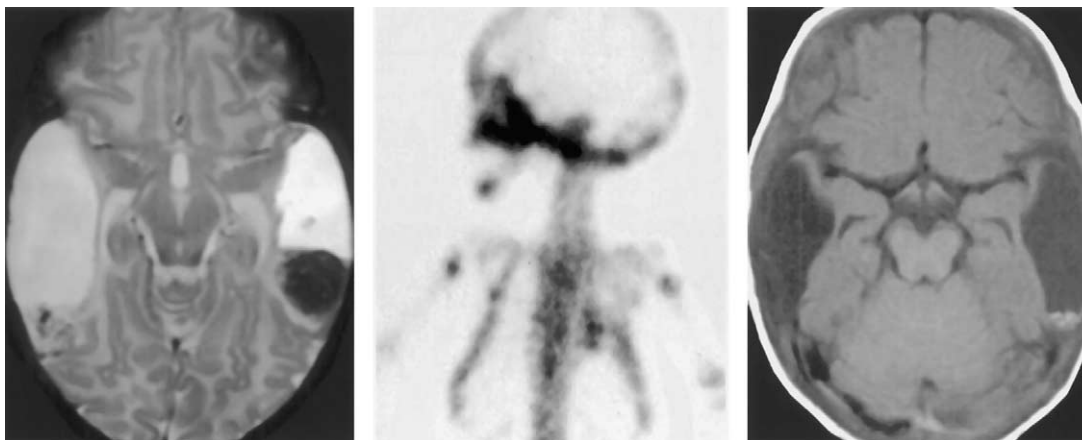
Axial T2-weighted image of young victim of nonaccidental trauma demonstrating unusual bitemporal hematomas (*left*). Mass effect has resolved by the time of the MRI. Note the heterogeneity of the cystic hemorrhagic collections. Nuclear medicine study demonstrates increase uptake of posterior ribs, consistent with rib fractures (*middle*). Subsequent T1-weighted image from subsequent MRI demonstrates the malacic changes of temporal lobes seen earlier on the T2-weighted images (*right*).
